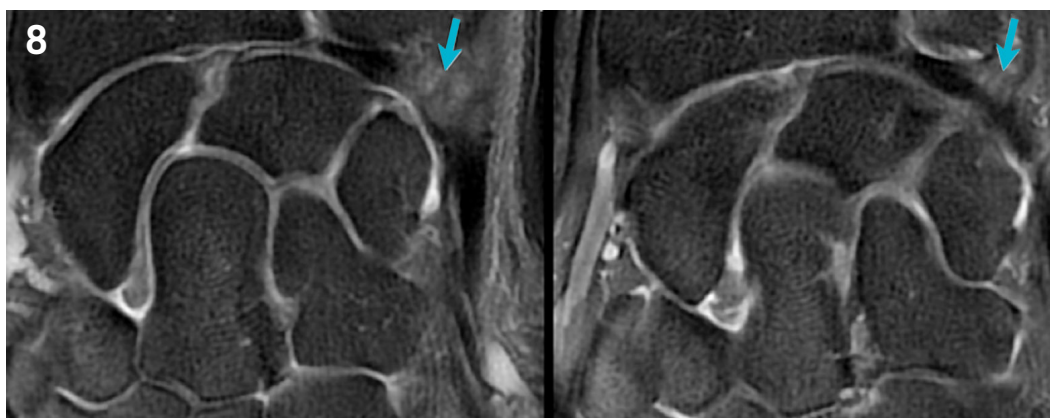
False-positive of an ulnar-sided tear due to presence of ligamentum subcruentum (arrow) which is a vascularised connective tissue appearing hyperintense on T2-weighted sequences at MRI.
